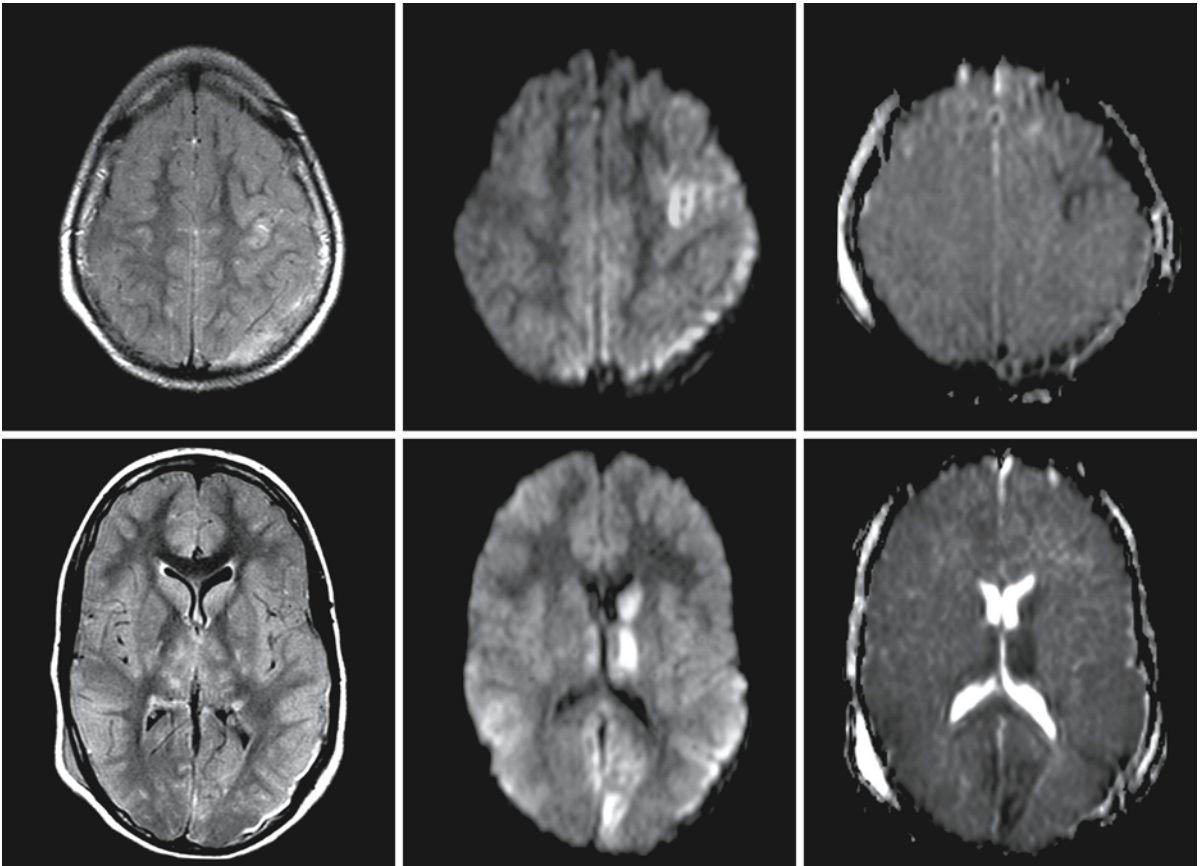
A 14-year-old girl was the victim of a traffic accident. The FLAIR images on the *left (first column)* show some subdural blood in the left occipital region and a lesion in the left frontal lobe. There are lesions in the basal ganglia and thalami. Diffusion-weighted Trace images (*second column*) show
